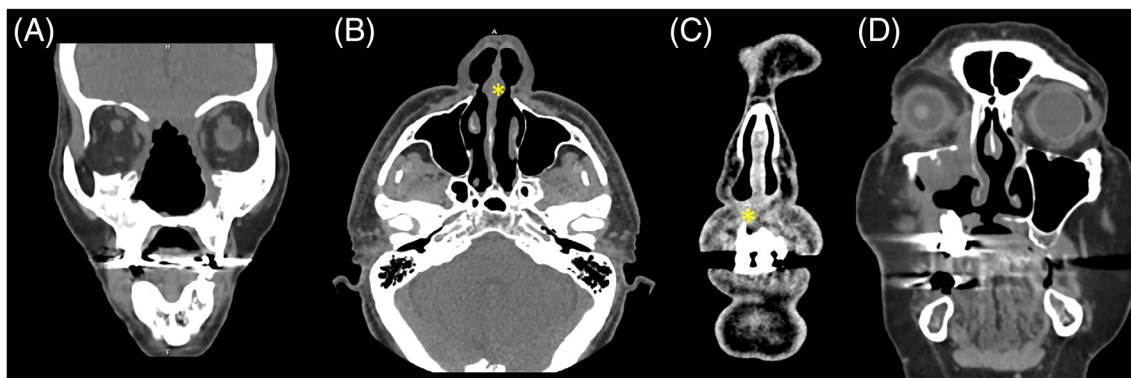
Total septal perforation, turbinates, lamina papyracea, and cribriform absent on coronal CT (A). Axial CT of bilateral anterior inferior nasal septal lesion (*) (B). Coronal CT showing right nasolabial pyriform aperture mass (*) (C). Destruction of hard palate and septum with right maxillary sinus mass and infiltration of lacrimal system on coronal CT (D)
